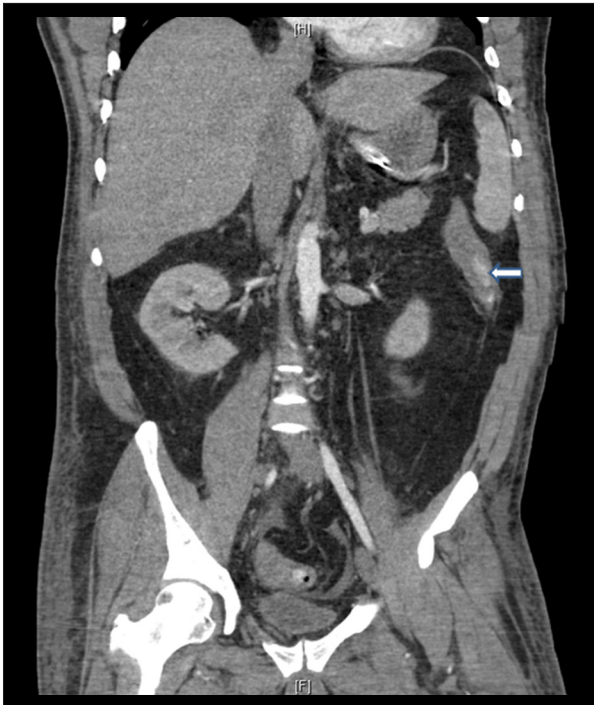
CT abdomen. Thickening of descending colon wall with hyperdense material in lumen, consistent with blood (arrow).
